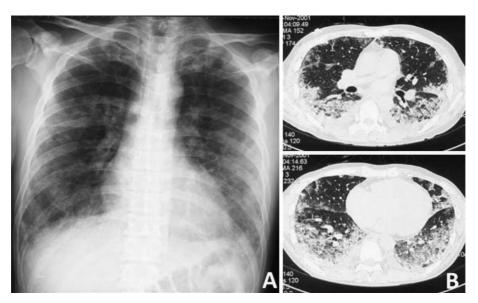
Chest X-ray (A) on admission showed bilateral reticular shadows in all lung fields. Chest CT (B) showed ground-glass opacities and consolidation in both lungs, with peripheral predominance and pleural effusion.
